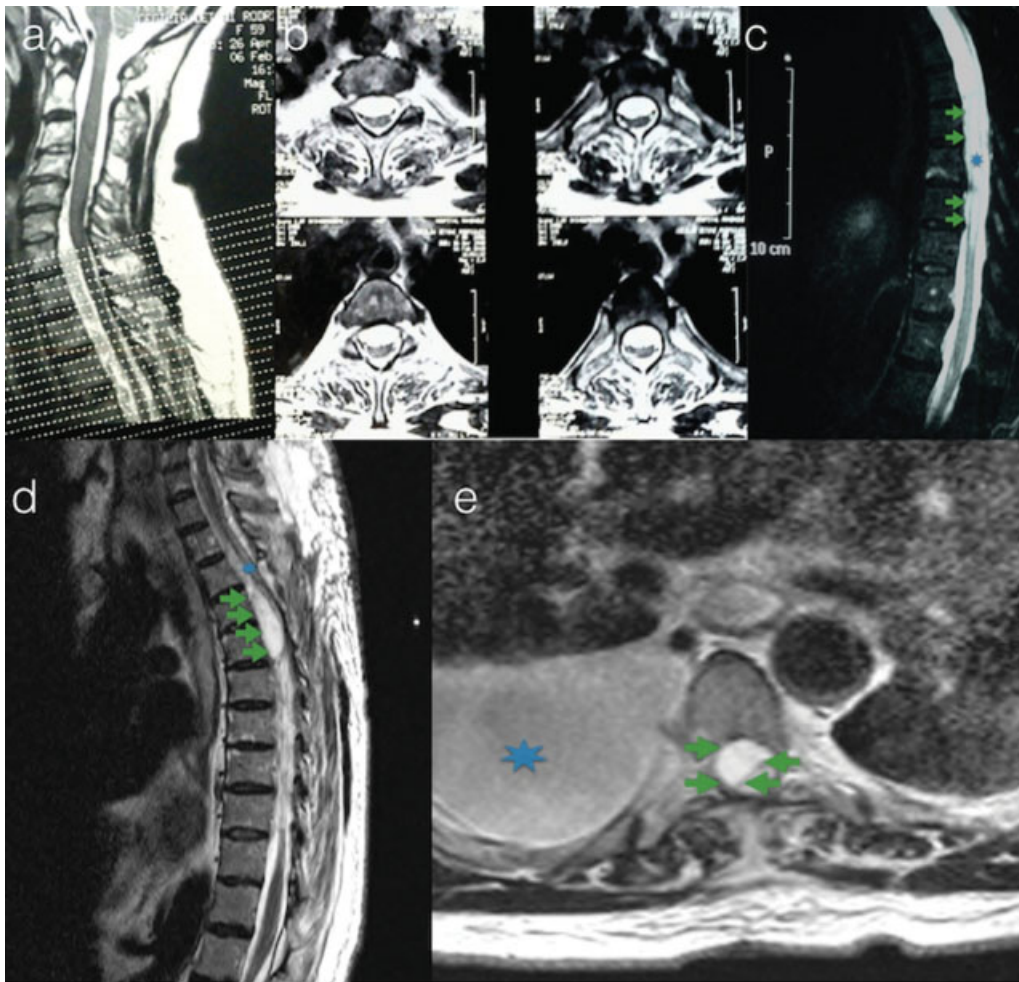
(a) Cervical pre-operative sagittal MRI of case 2. (b) Axial sections of preoperative thoracic spine MRI of Case 2. (c) Sagittal section of preoperative thoracic spine MRI of Case 2. It can be observed subdural arachnoid cyst (green arrows) and a significant edema (blue mark). (d) Postoperative sagittal MRI showing residual cyst (green arrows) and maintenance of medullary edema (blue mark). (e) Axial postoperative MRI showing right pleural effusion (blue mark), causing temporary dyspnea. Residual cyst located ventrally and to the right of the spinal cord (green arrows)
